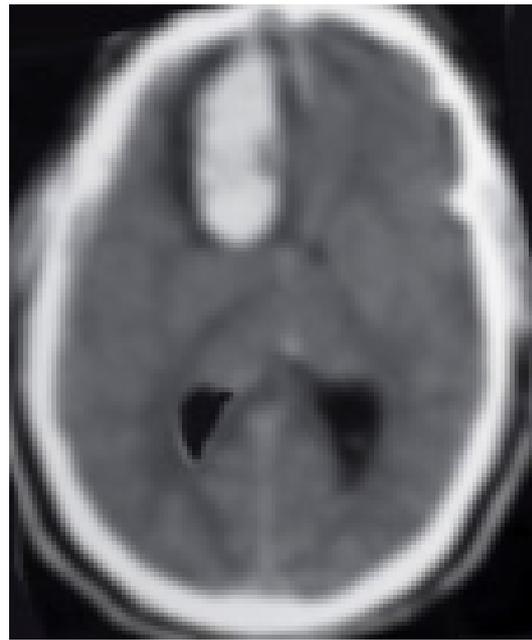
CT image of frontal intracerebral lobar hematoma
